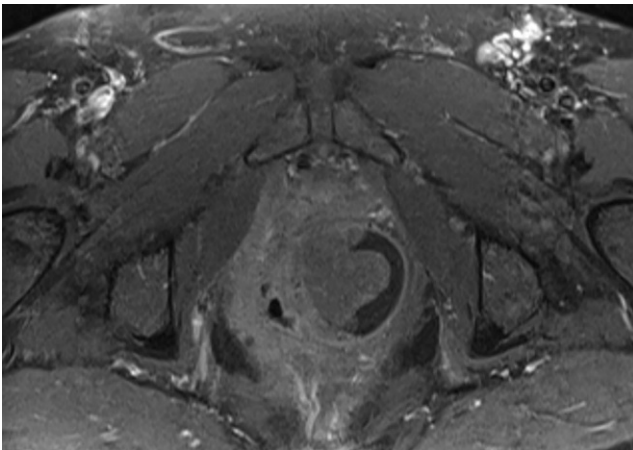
Pre-treatment axial MRI scan from January 2018. A 3 cm wide pararectal cavity on the right side filled with liquid and air was retrospectively interpreted as a possible origin of the developing gangrene
